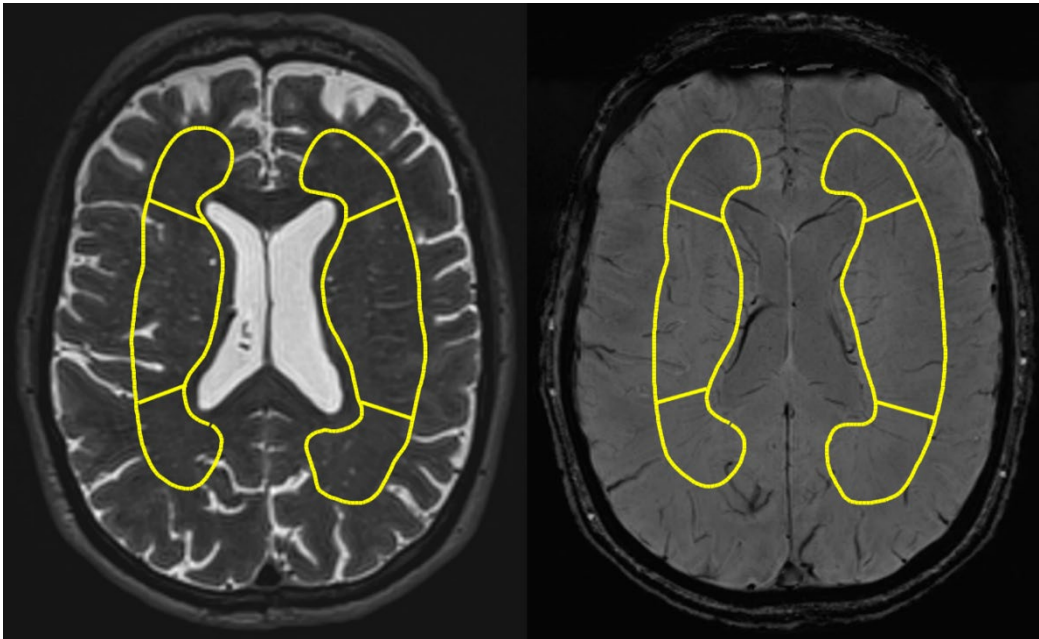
An example of the final ROI in T2-weighted image (left) and susceptibility weighted imaging (right).
